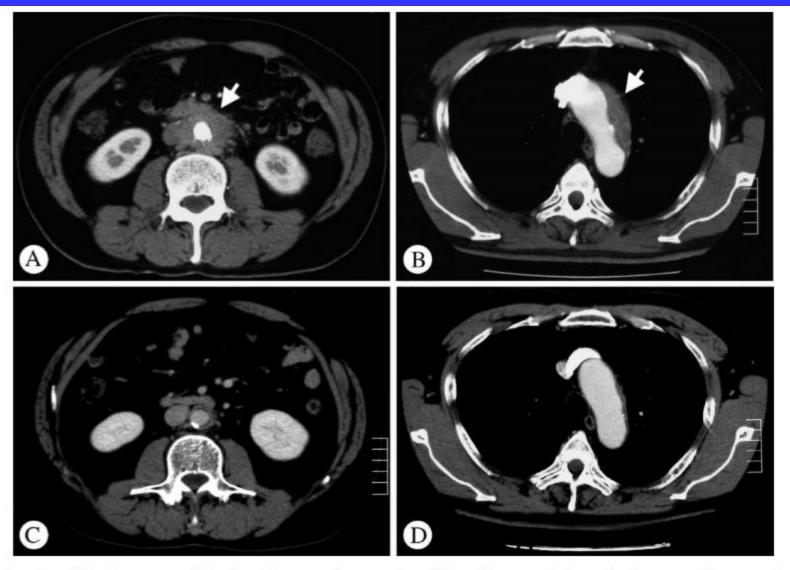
A and B, Contrast material—enhanced computed tomography of the abdomen and chest showing paraaortic masses in the retroperitoneum and mediastinum before corticosteroid therapy (arrows). C and D, The paraaortic mass was markedly reduced in size after corticosteroid therapy for 8 weeks.
